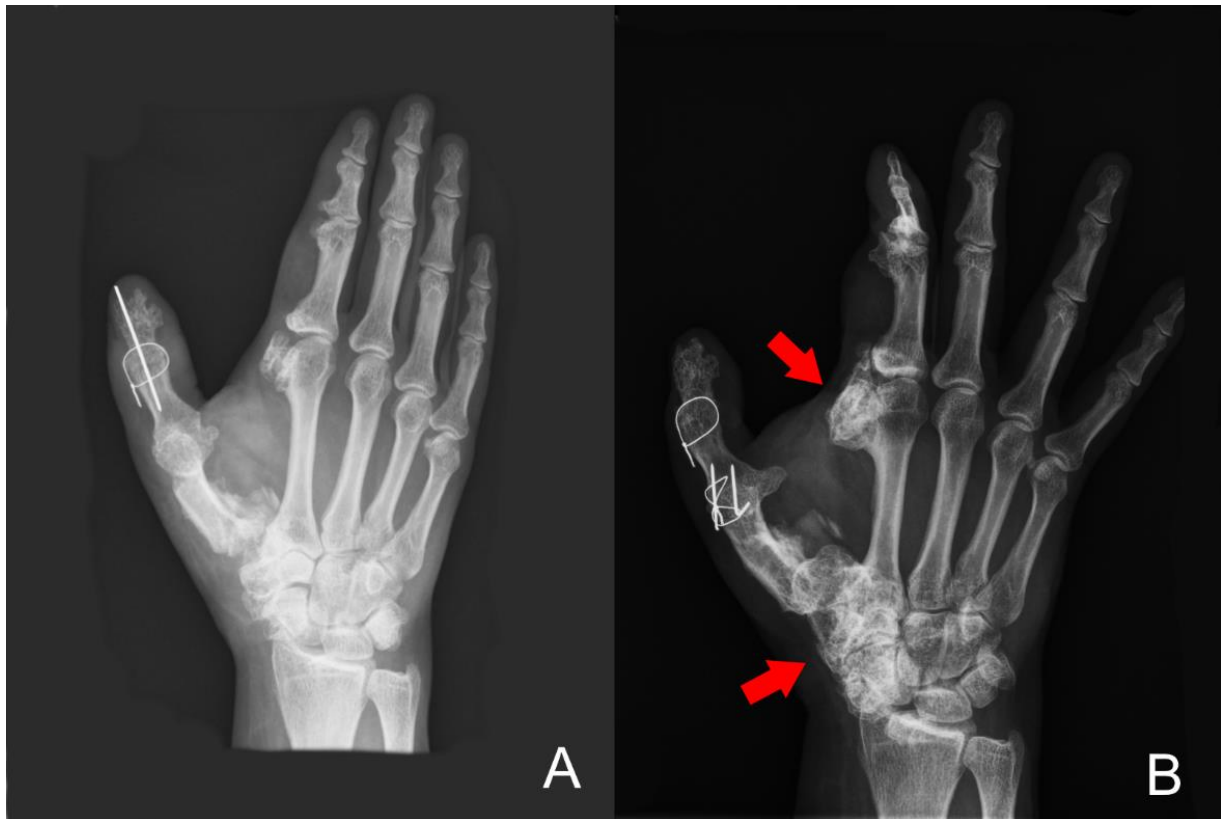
Conventional radiograph of the right hand of case 4, showing progression of juxta-articular new bone formation between age 38 (8A) and age 47 (8B). In particular, the thumb and index finger (upper arrow) and the scaphoid, trapezium, and trapezoid (bottom arrow) show severe progression.
